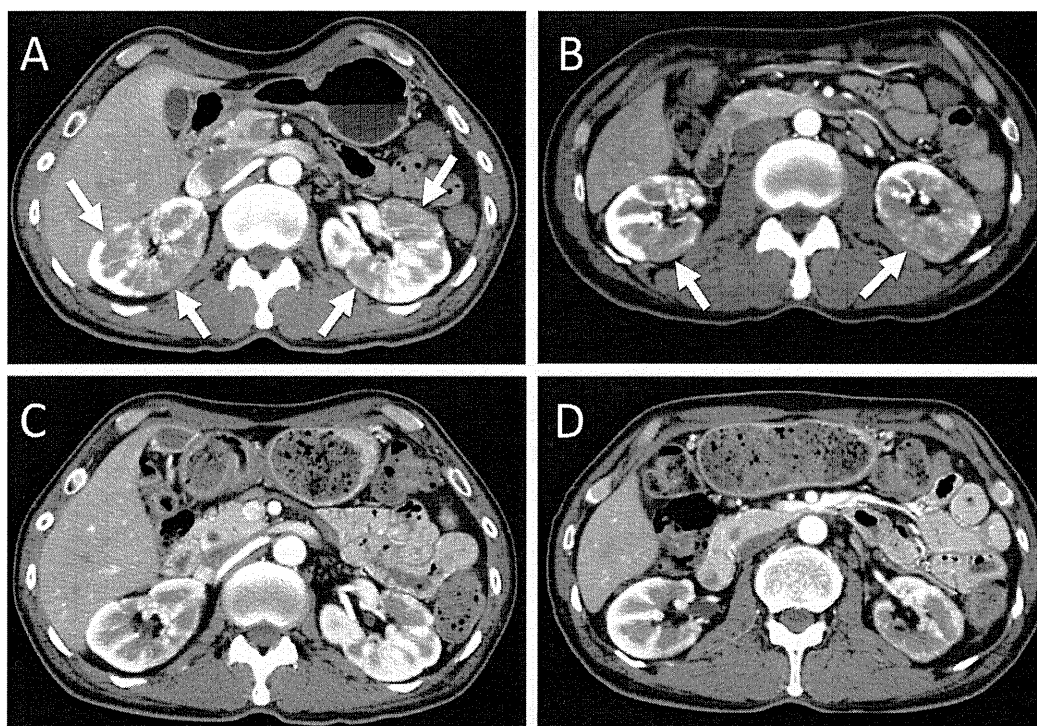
Contrast-enhanced computed tomography of the abdomen before (A, B) and after (C, D) treatment. Multiple low-density lesions in both kidneys were observed (A, B), which were ameliorated after steroid administration (C, D). Arrows indicate the abnormal regions in the kidneys.
